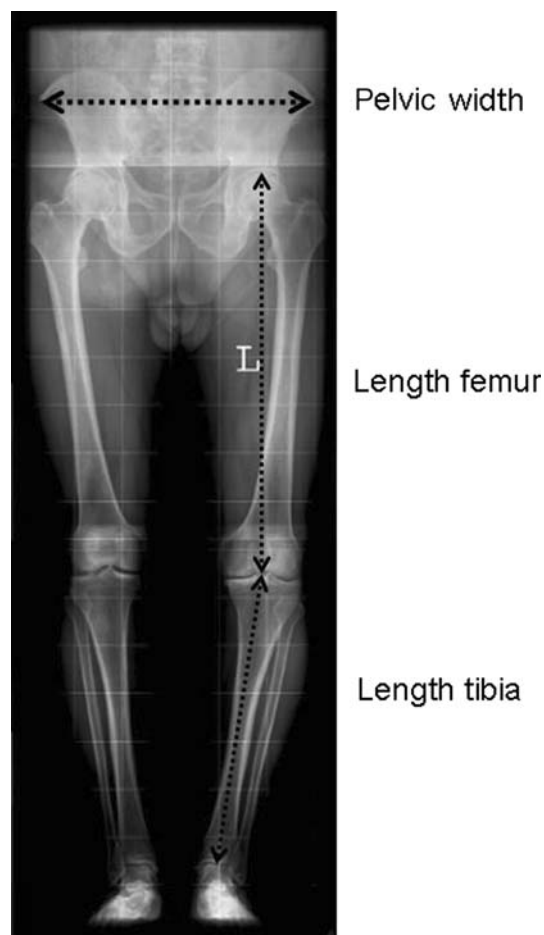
On this picture, the measurements on the calibrated full leg radiographs are shown to determine the pelvis width/total leg length ratio.
